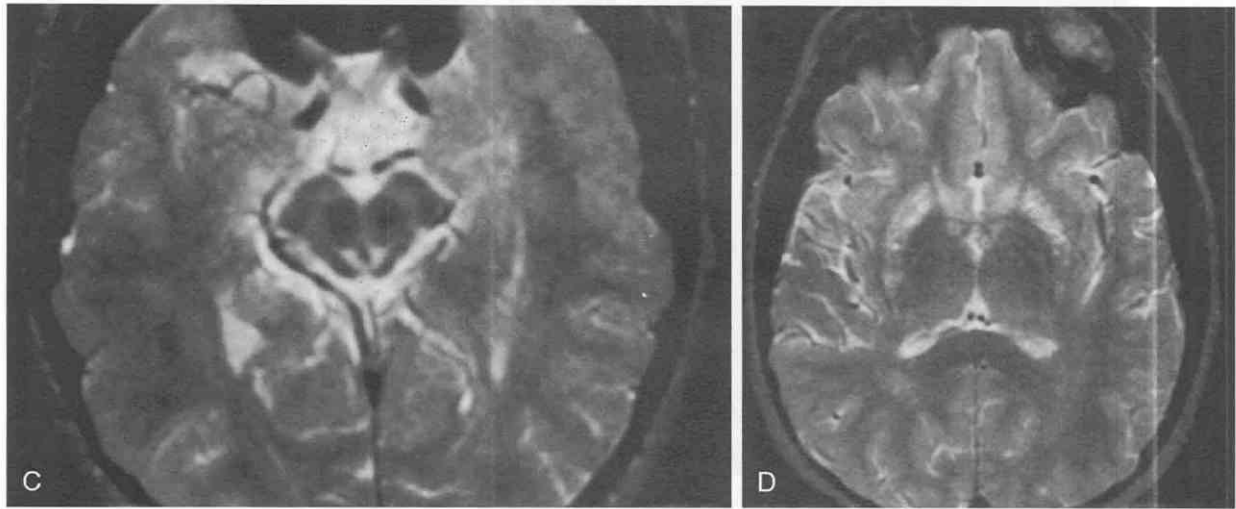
Continued.* C, T2-weighted axial image at the midbrain level. The previously seen hyperintensities have resolved almost completely, leaving only small periaqueductal foci. D, There is residual persistent hyperintensity in the putamina bilaterally.
